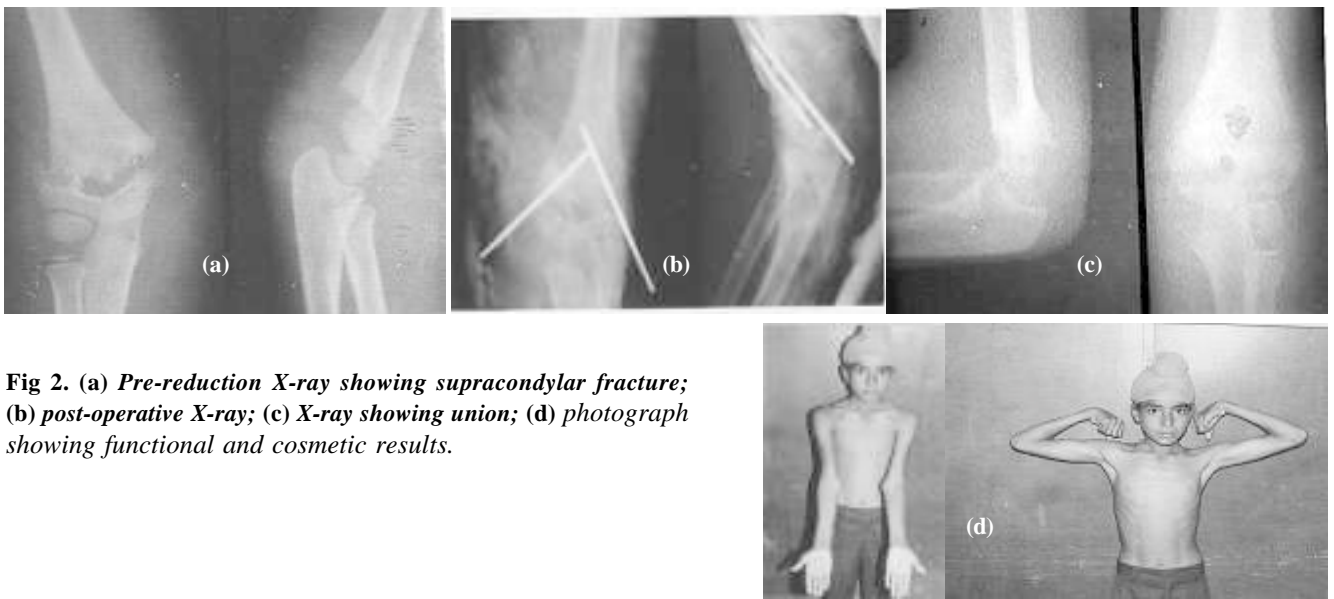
(a) Pre-reduction X-ray showing supracondylar fracture; (b) post-operative X-ray; (c) X-ray showing union; (d) photograph showing functional and cosmetic results.
